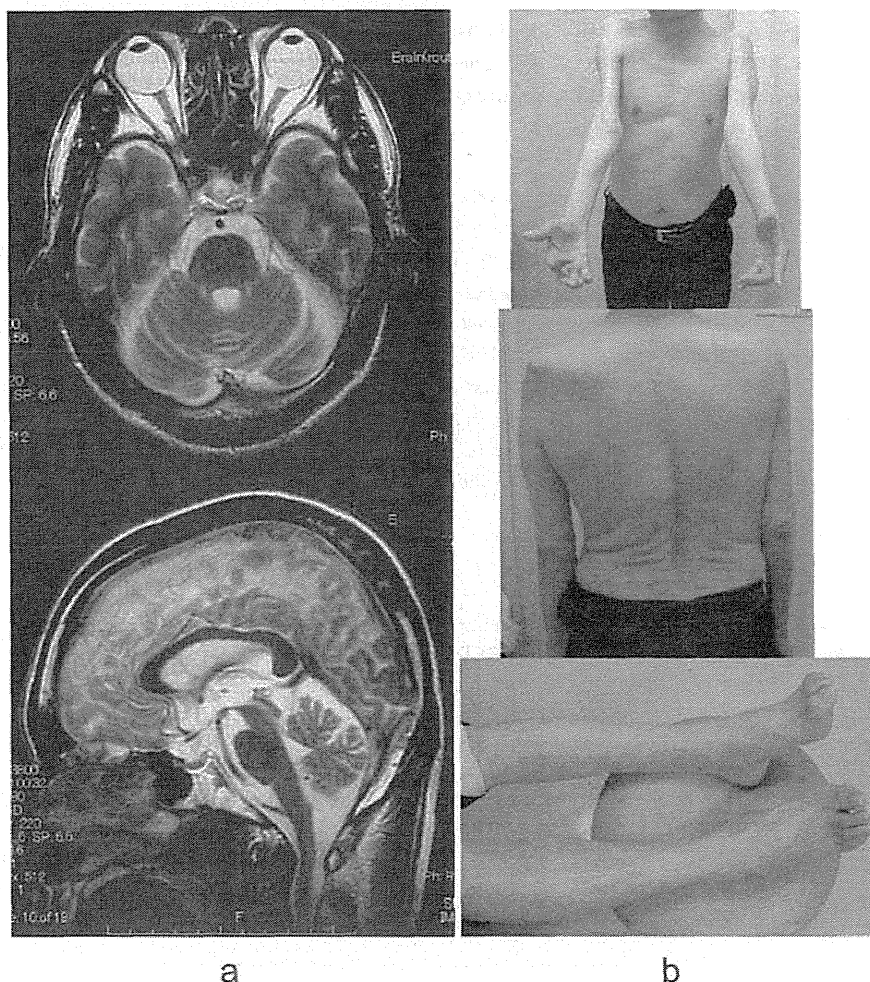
Brain MRI of case 1 (III-13) (a) and pictures of case 3 (III-12) (b).
